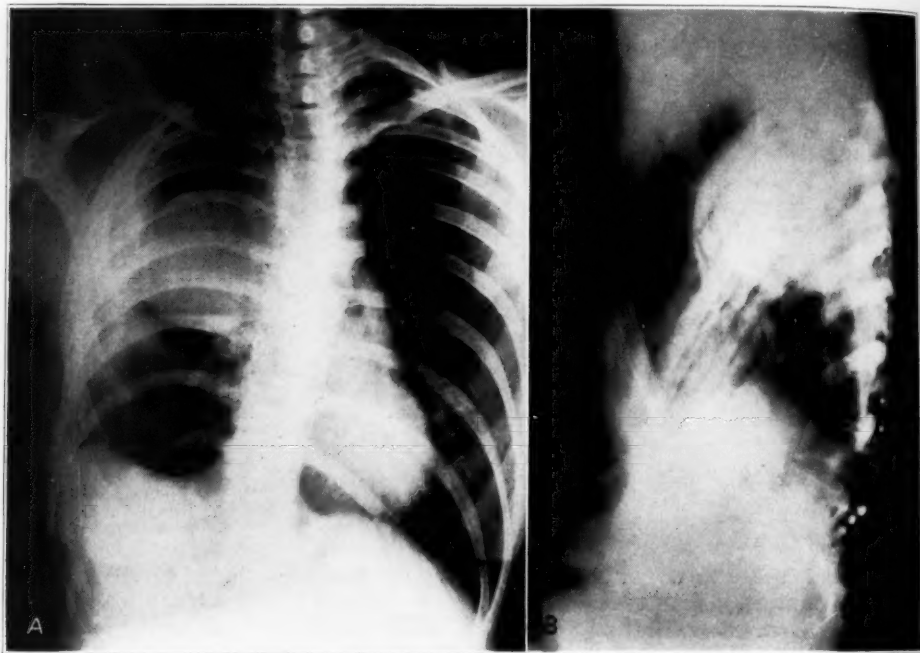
(case 10).—*A*, anteroposterior roentgenogram, showing a large tumor of the chest which was connected through an intervertebral foramen with an intravertebral tumor at the same level. *B*, lateral view of the tumor seen in *A*.
